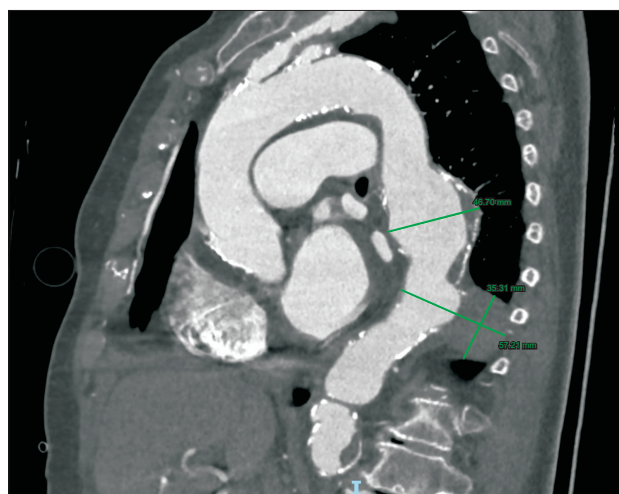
Thoracic computed tomography scan showed dilated descending aorta (maximum diameter 47 mm with parietal calcifications and thrombotic apposition) and penetrating aortic ulcer (maximum axial diameter 57 mm and cranio-caudal extension 40 mm).
